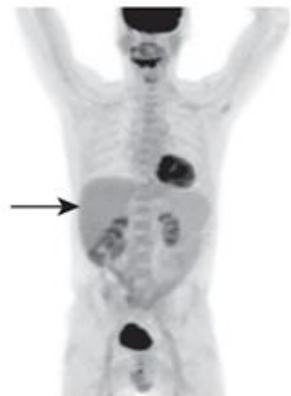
Attenuated corrected maximum intensity projection image from the same FDG PET scan as Fig. 1.1. Arrow points at the liver surface, which after attenuation correction appears to have the same photon counts as the deeper portions of the liver.
